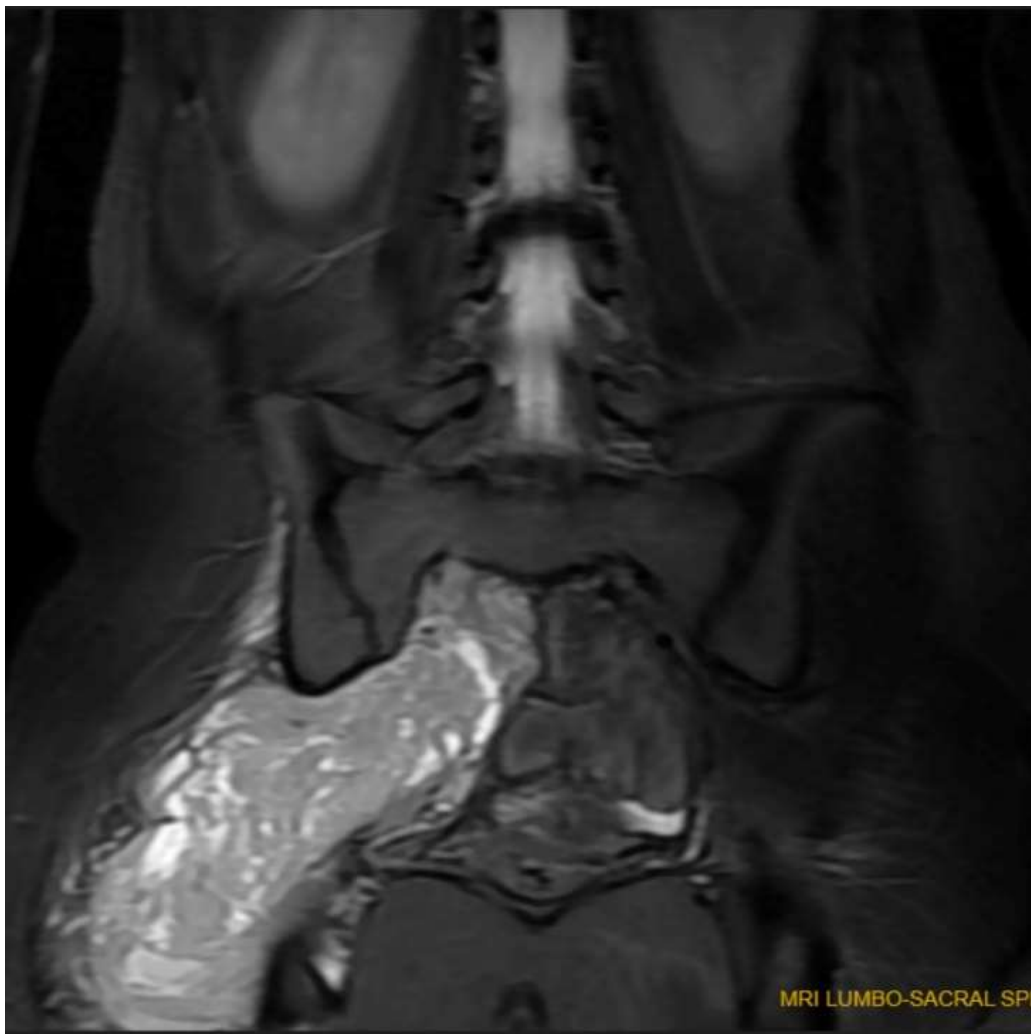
MRI lumbosacral spine showing tumour arising from s1 and s2 nerve roots
